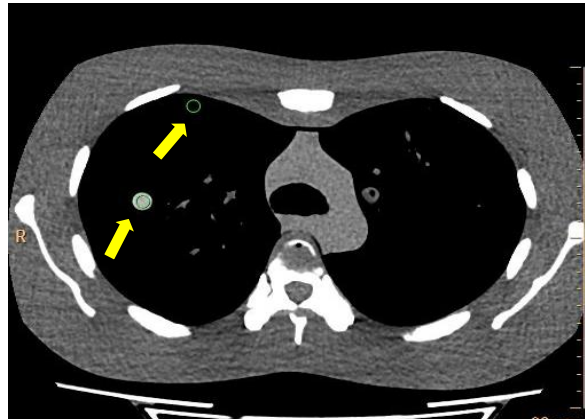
10 Measurement the CT number of nodule and background
